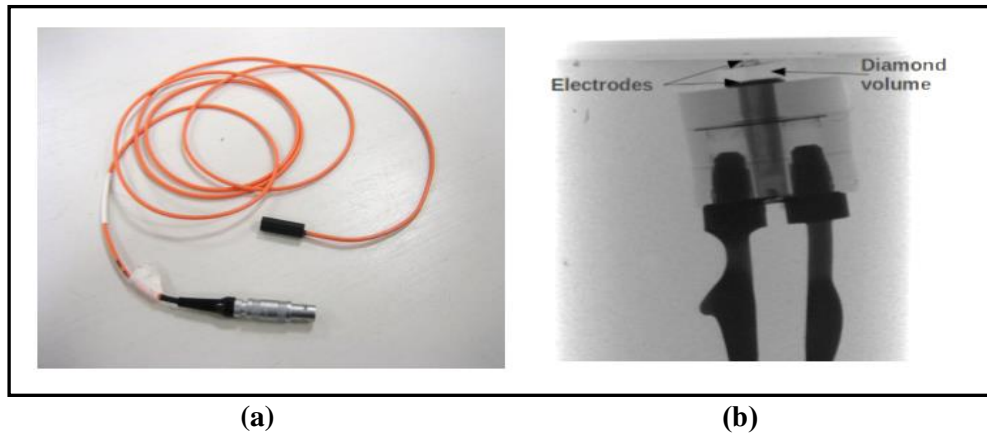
Photographs of DD4 detector (a) and radiograph of the detector (b) [13]
